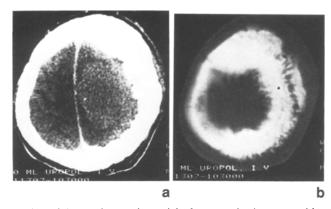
a) CT-scan shows a large right fronto-parietal tumour with slight contrast enhancement. b) CT-scan (bone window) – extensive involvement of the skull by the tumour
